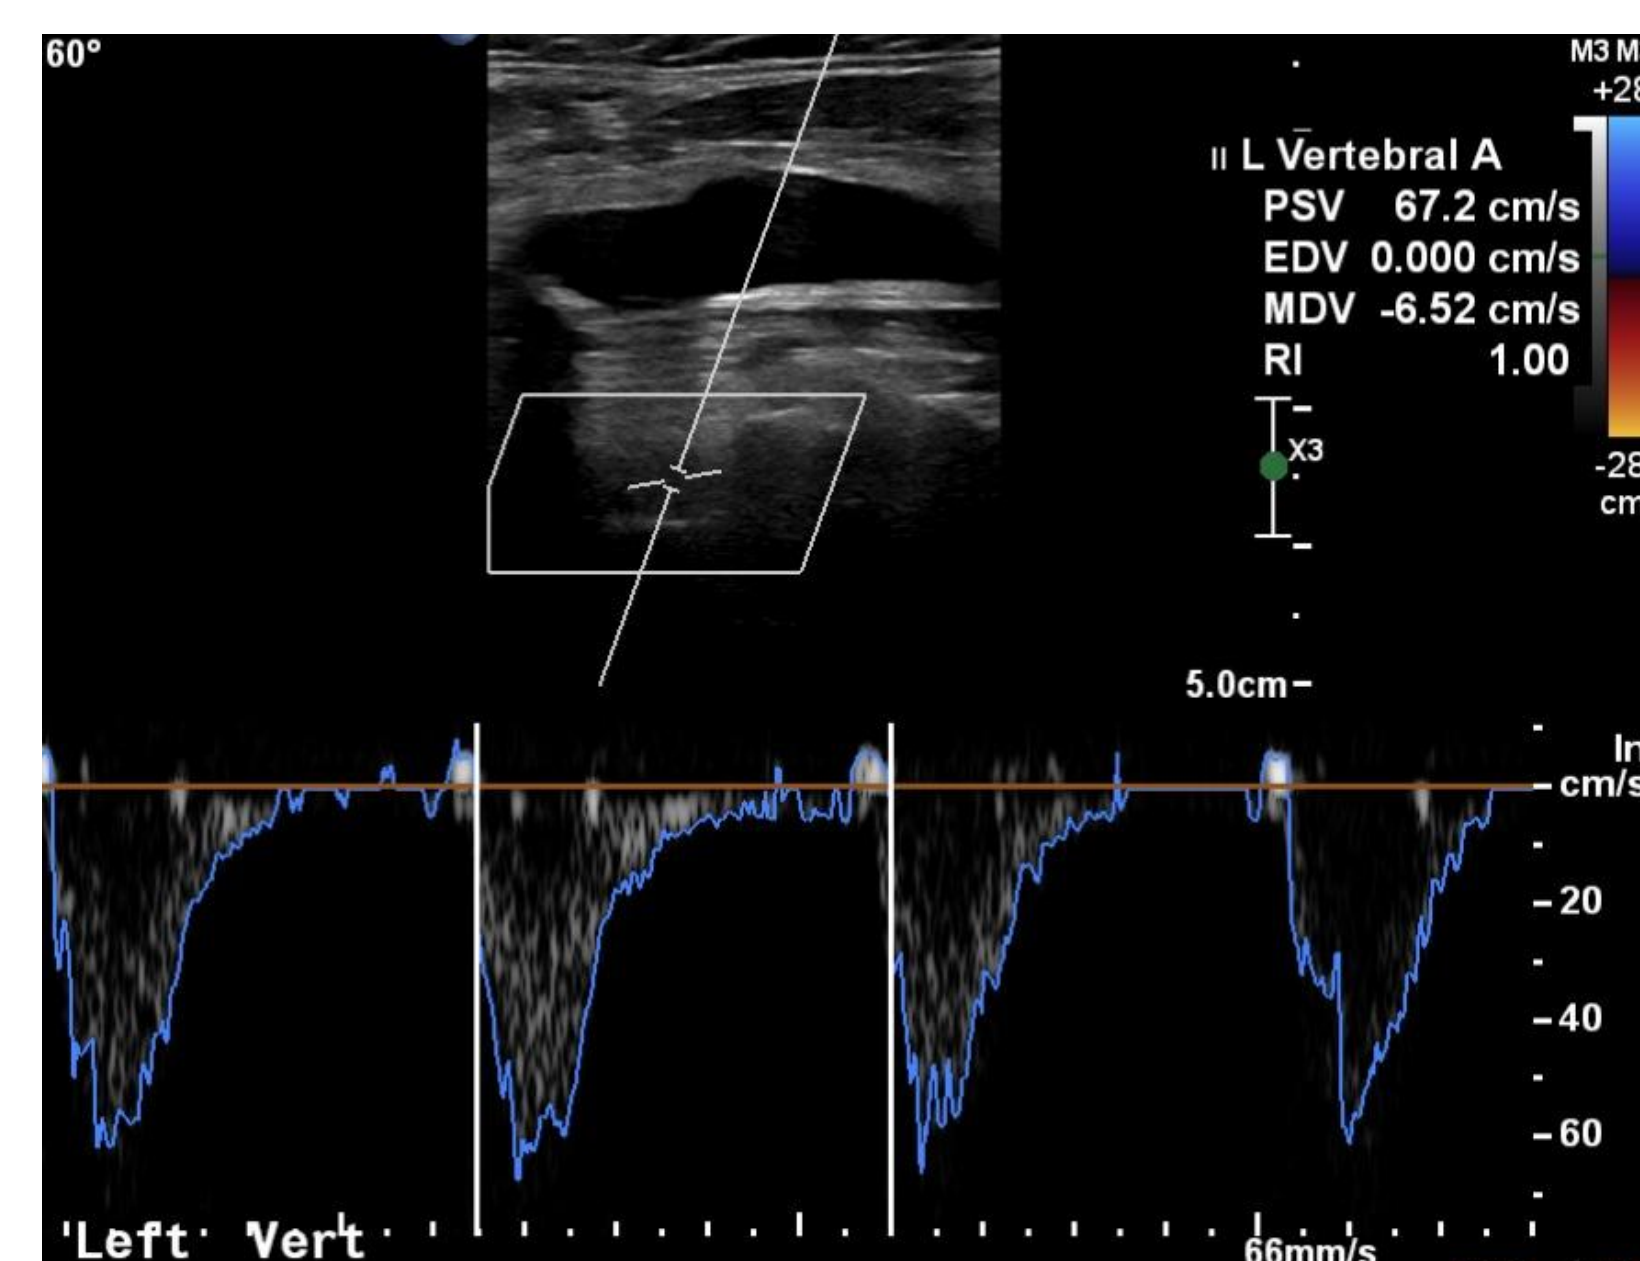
Reversed flow in Left Vertebral Artery on doppler US
